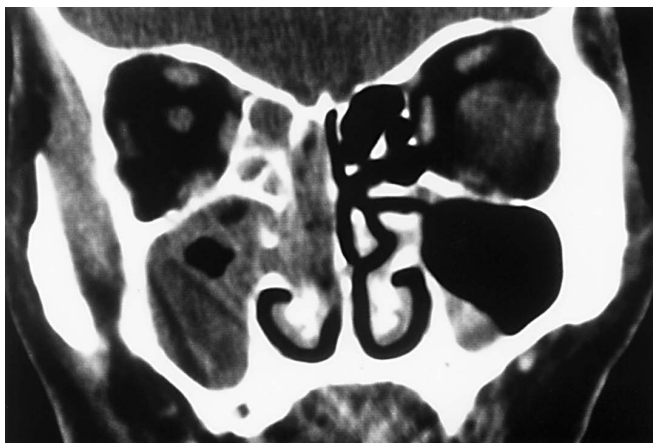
PNS CT scan showing a soft tissue mass occupying the right ethmoid sinus
